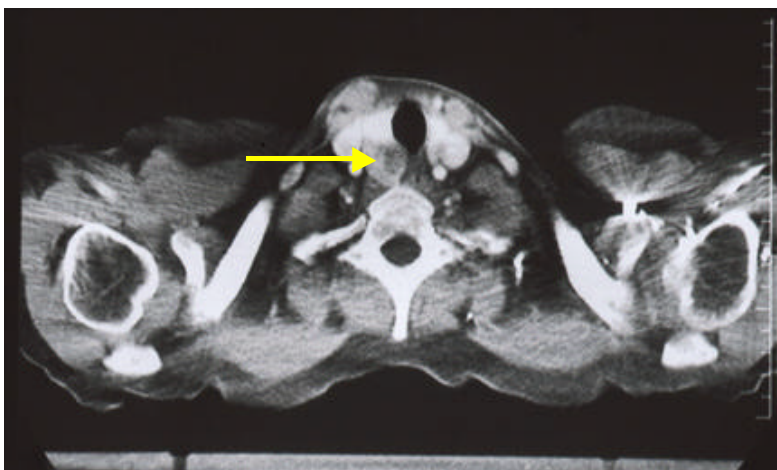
CT scan of the neck demonstrating a solitary nodule in the posterior aspect of the right lobe of the thyroid gland.
